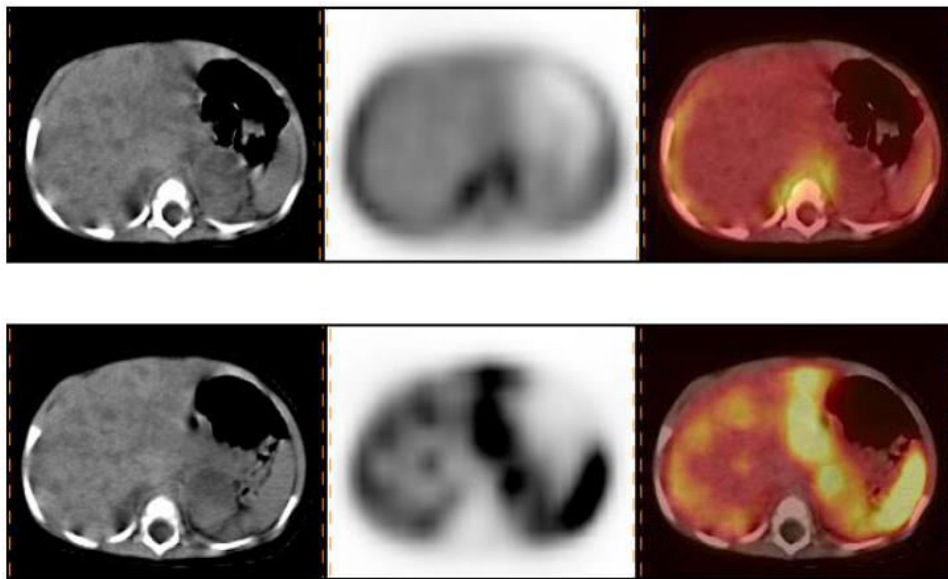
F18-FDG PET-CT for response evaluation in neuroblastoma: Coronal sections of CT, PET and PET-CT scan showing increased FDG uptake in right suprarenal mass (primary) with liver lesion and right paraaortic lymph nodes metastasis (upper row). Follow-up PET-CT scan after 6 cycles of chemotherapy, demonstrated resolution of primary and metastases suggestive of good response (lower row)
